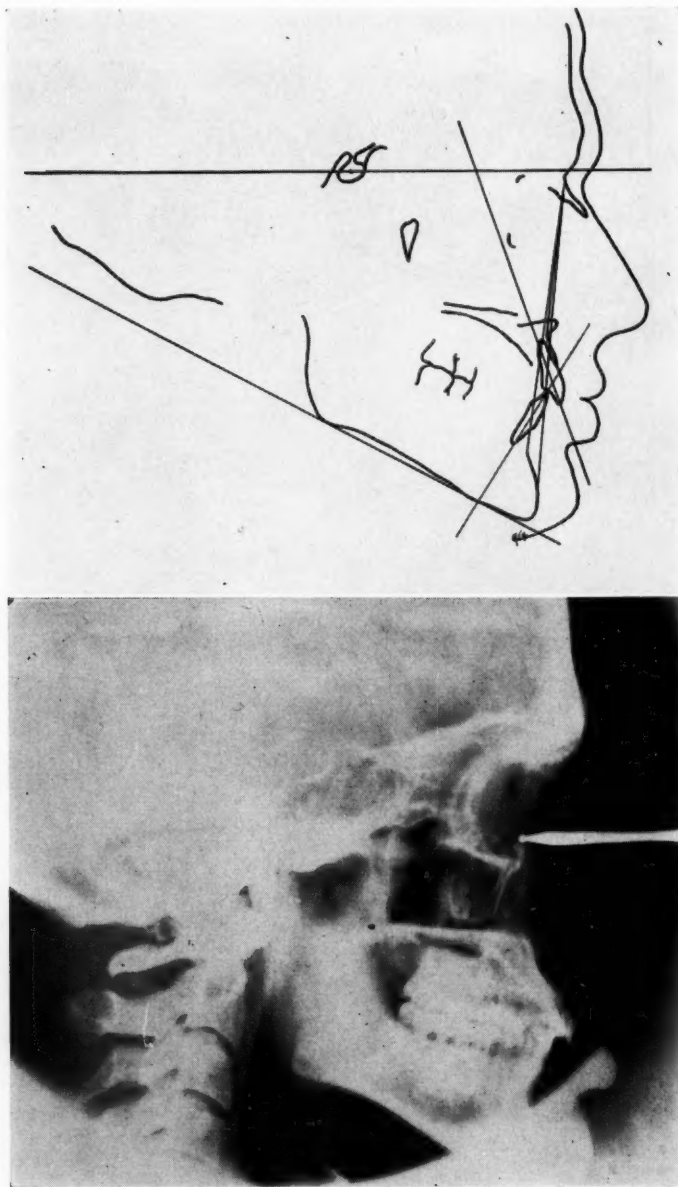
Patient W. S. Cephalometric radiograph and tracing in acquired terminal occlusion.
